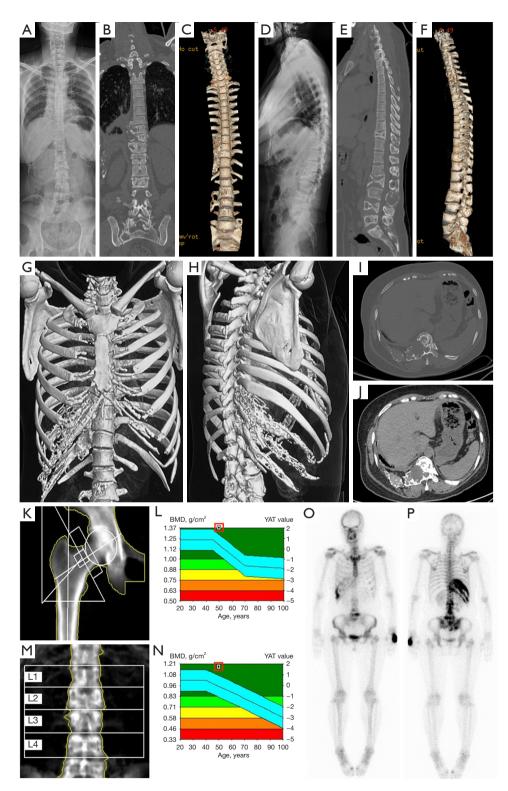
Initial imaging of this Gorham-stout disease case. (A-F) Frontal and lateral views of the full spine on X-ray and computed tomography scans. (G,H) Frontal and posterior views on emission computed tomography bone scans. (I,J) Frontal and right lateral views on CT scans of 3D reconstructions of the thorax. (K,L) Cross sections from CT scans in lung and bone windows. (M-P) Bone densitometry of the femoral neck and lumbar spine suggesting normal conditions. BMD, bone mineral density; YAT, young adults T value.
